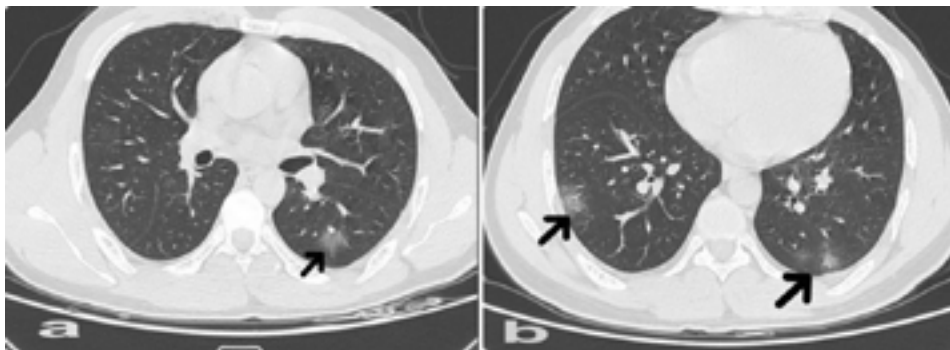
Chest computed tomography shows a) Infiltration in ground-glass opacity in the left lower lobe superior segment and b) Multifocal peripheral and subpleural ground-glass opacity in the bilateral lower lobe basal segments
